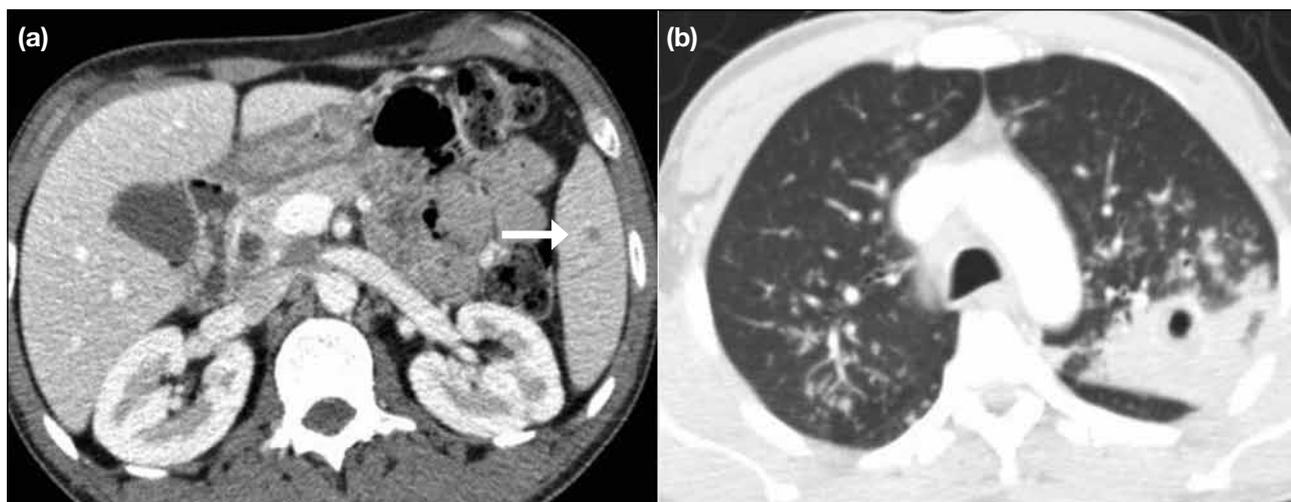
A 46-year-old male with tuberculosis of spleen: (a) axial image of contrast-enhanced computed tomography showing a hypoenhancing lesion in spleen (arrow); and (b) consolidation with cavitation in left upper lobe in keeping with tuberculous infection.
